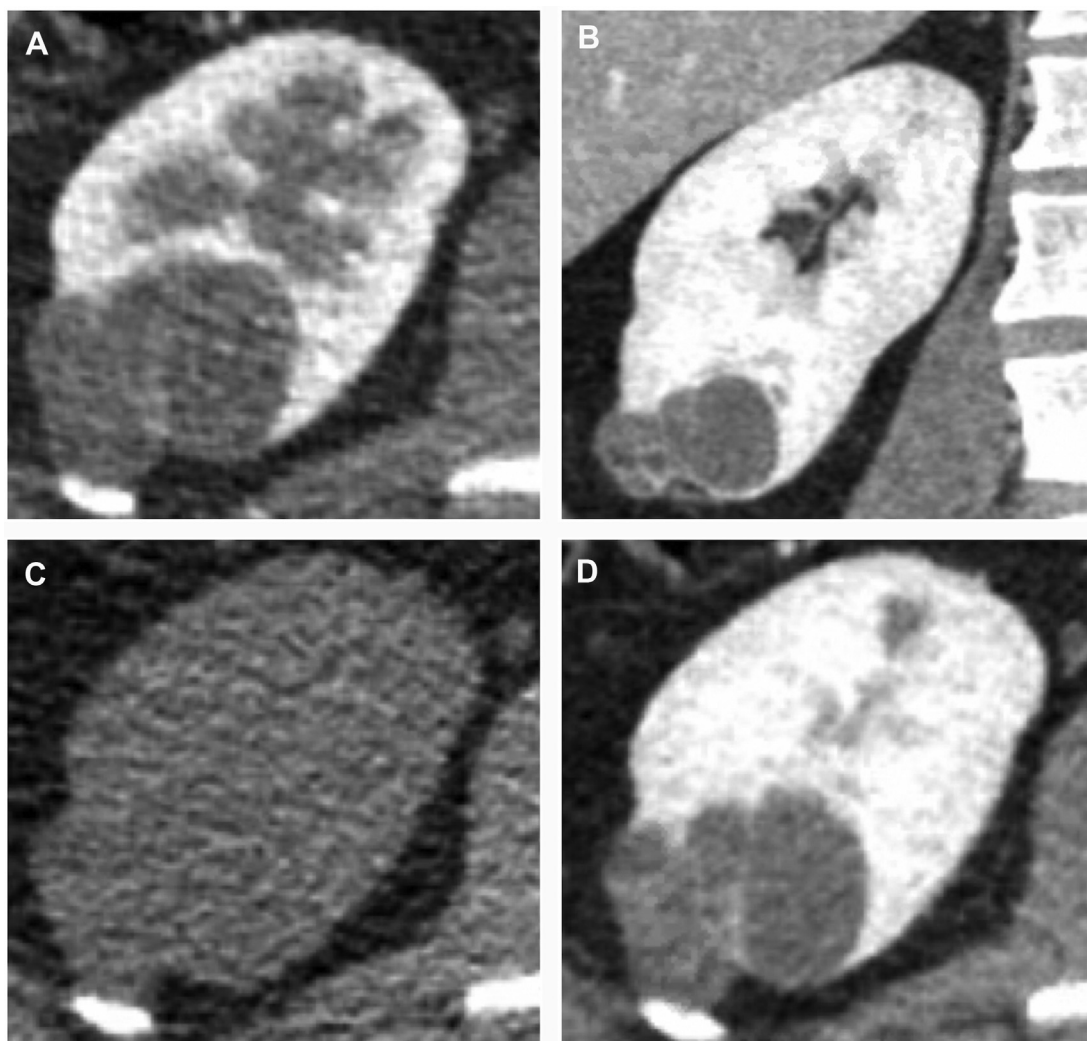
A 63-year-old man with incidental discovery of a well-defined right renal mass on axial (A) and coronal (B) portal venous CT images. The hypoattenuating component of the mass measures fluid in attenuation and comprises 75% or more of the mass, indicating that it is cystic. Multiple thin internal septations are seen with probable enhancement. This mass could be classified as a Bosniak type IIF renal cystic mass based on these features, but a subsequent renal CT scan was ordered. Axial noncontrast (C) and axial corticomedullary phase (D) images from the renal CT scan confirm the presence of multiple thin enhancing septations, and this was correctly classified as a Bosniak type IIF renal cystic mass.
